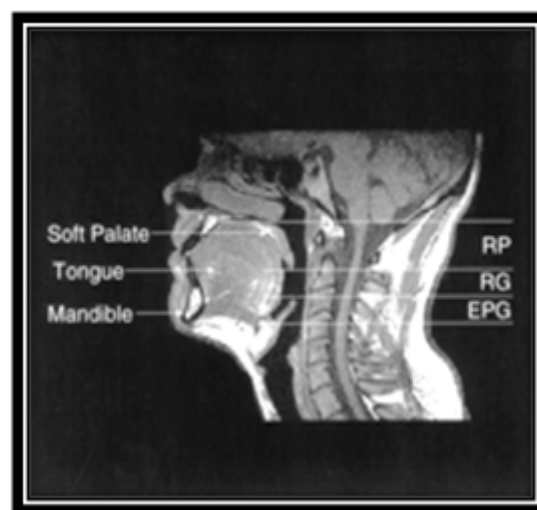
MRI of Pharyngeal Airway.
